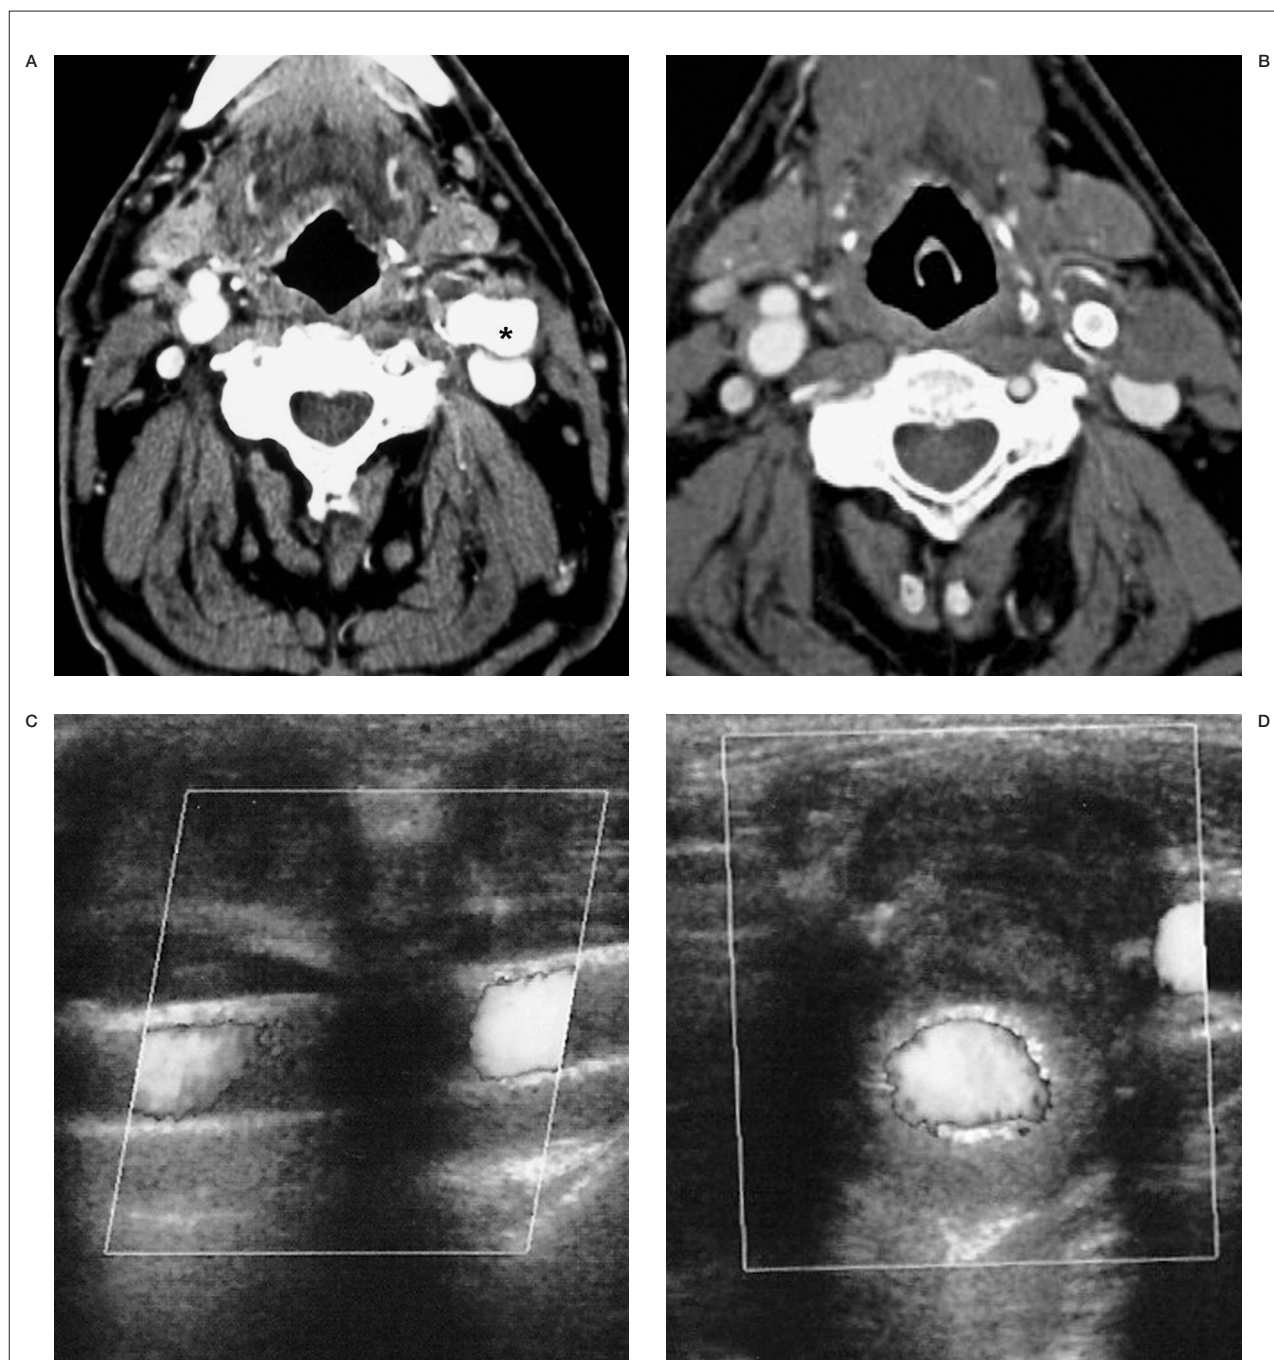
CT angiography before stents placement (A) shows the carotid artery pseudoaneurysm (*) with compression on the jugular vein. After placement of three stents there is complete exclusion of the pseudoaneurysm (B) with no flow inside the sac, which is also apparent in the late phase. Color Doppler US performed three months after treatment (C,D) shows a patent carotid artery and almost complete pseudoaneurysm exclusion.
